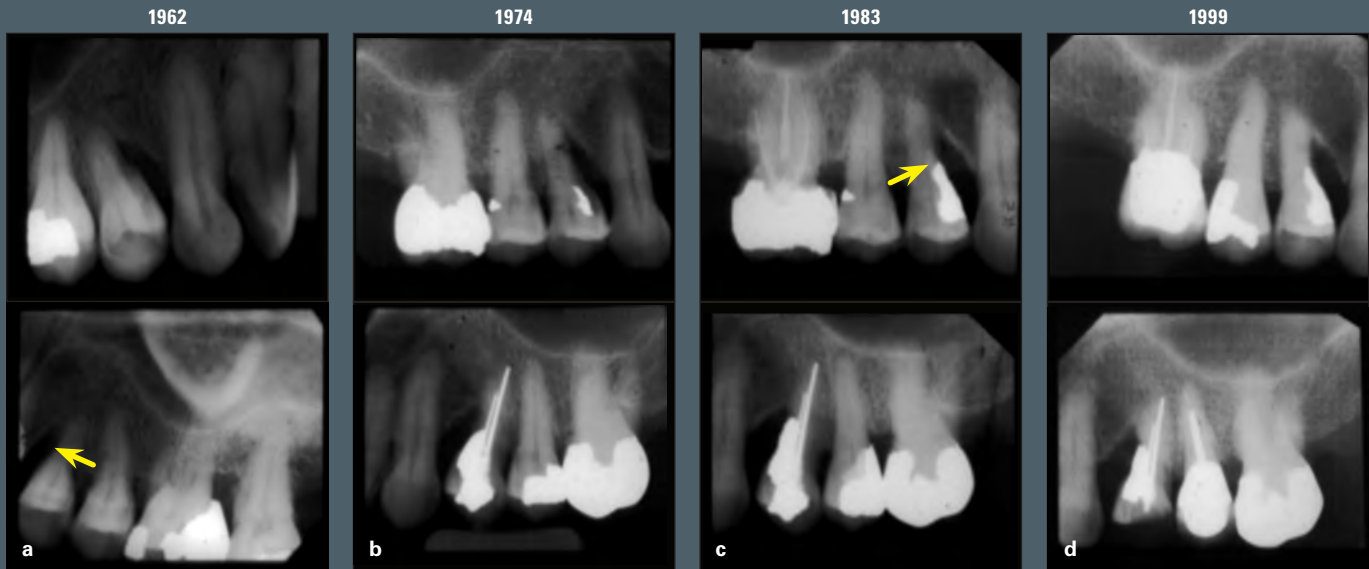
This patient first presented in the year 1962 (a). Finances prevented the extraction of the maxillary first premolars and the construction of fixed partial dentures. These radiographs taken at 12 (b), 21 (c), and 37 (d) years show that the first premolars remained in the patient's mouth for 37 years with no corrective therapy. The recall interval was 3 months, and the patient continued to be punctual until her death. This is an example that must be looked at as an outlier.
